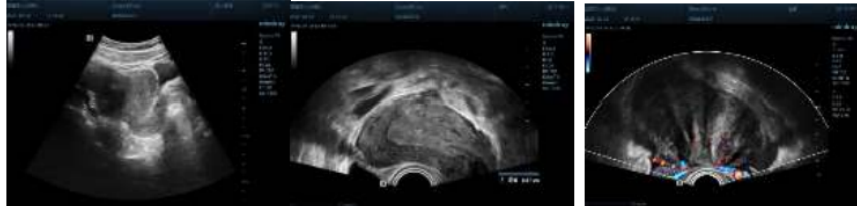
Results of pelvic gynecological ultrasonography
